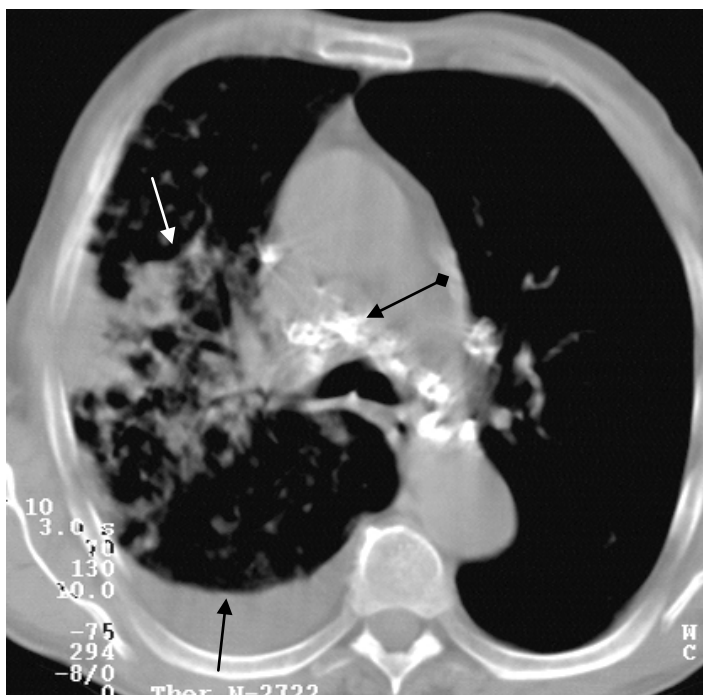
CT-scan of thorax at the level of tracheal bifurcation. Nonhomogeneous increase of density of pulmonary tissue with indistinct contours within the upper lobe on the right (white arrow). Pleural effusion on the right (black arrow). Calcified lymphnodes of mediastinum (arrows with rhombus). Infiltrative tuberculosis of the upper lobe of right lung. Exudative pleurisy on the right
